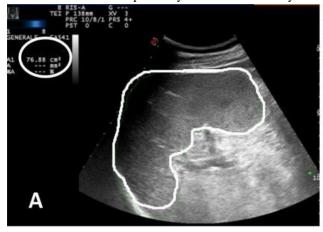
Ultrasound of Liver, A Normal liver; B Liver cirrhosis
